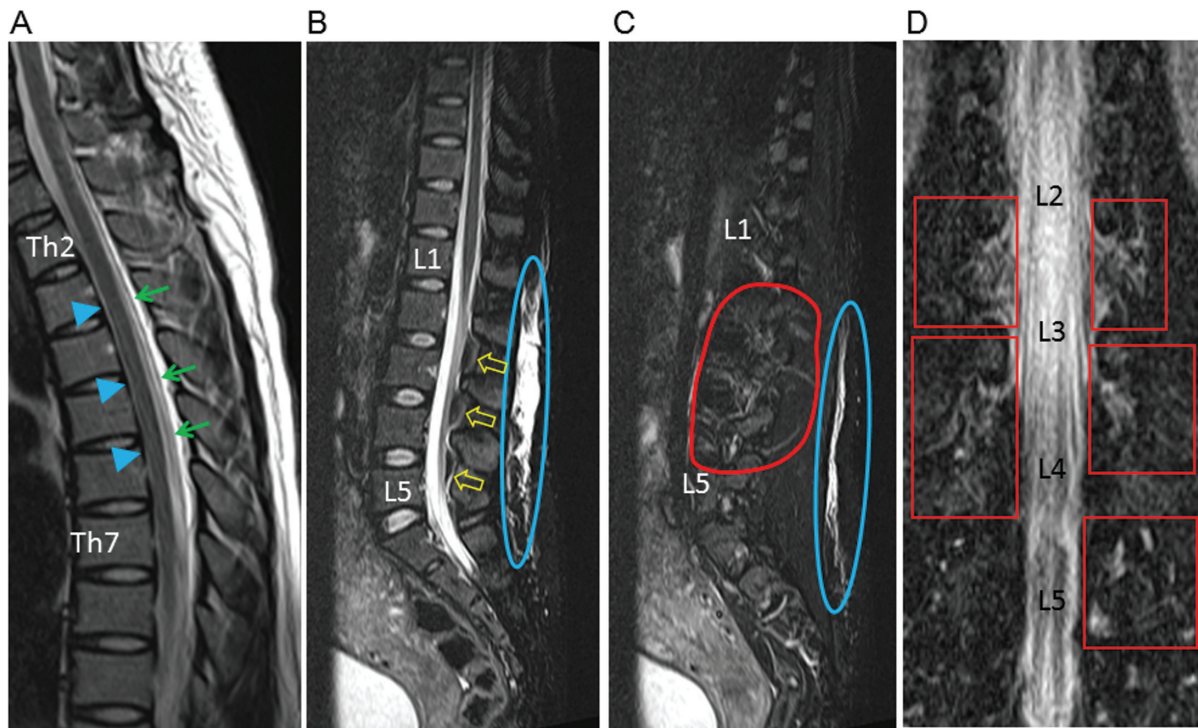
Spinal MRI at presentation of severe orthostatic headache in case 1. Midsagittal T2-weighted image (T2WI) at the thoracic level (A) showing an anterior shift of the spinal cord (arrowheads) and dura mater behind the cord (arrows). Midsagittal T2-fat saturated (T2-FS) images at the lumbar level (B) show the dinosaur tail sign (DTS) (open arrows) and cerebrospinal fluid collection (blue ellipse) behind the spinous processes. The left paramedian sagittal T2-FS image at the lumbar level (C) shows exudation of the CSF around the dural sleeves (encircled by red line). Coronal T2-FS image at the lumbar level (D) shows CSF exudation resembling a network around the dural sleeves into the paravertebral space (red squares).
